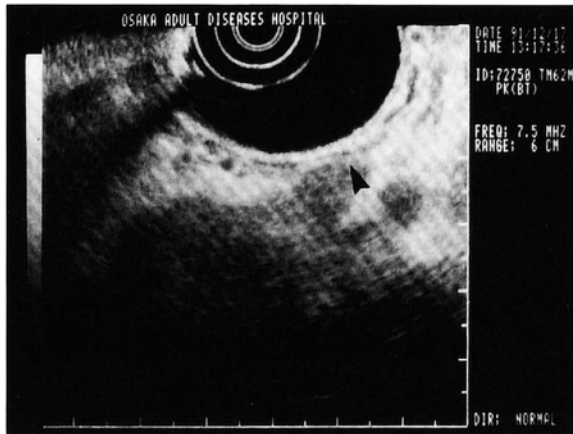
An endoscopic sonogram of a patient with pancreatic cancer directly invading the gastric wall. The tumor extended to the middle layer of the gastric wall.
